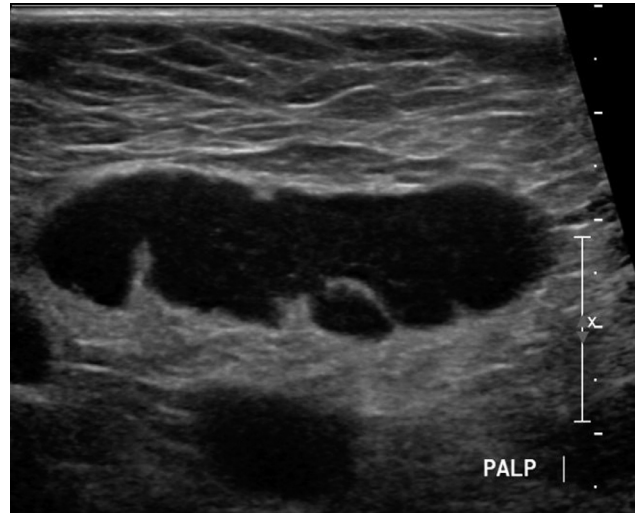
Ultrasound exam of right axilla. There is diffuse cortical thickening in an enlarged lymph node measuring 4.9 x 4.9 x 1.4 cm, correlating with the mammographic finding.
